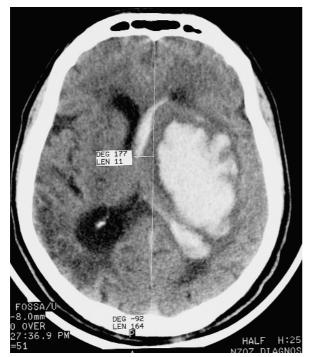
CT of the head before the operation
